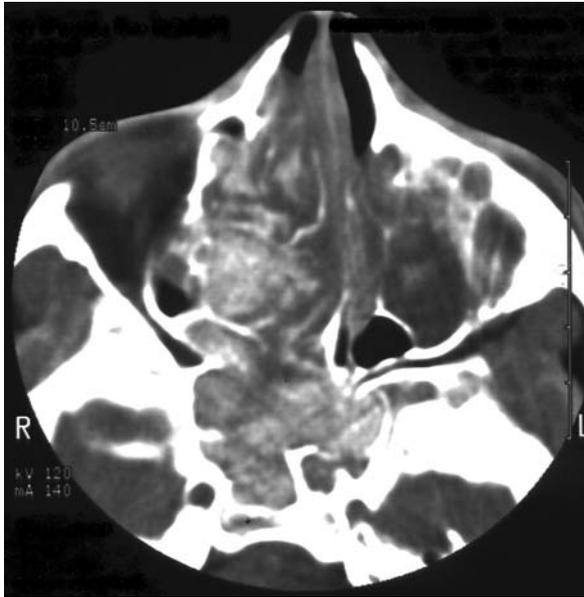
Axial computed tomography scan of the sinuses in soft tissue windows. This shows multiple opacified sinuses bilaterally and hyperdense sinus contents within the right ethmoid and sphenoid sinuses
